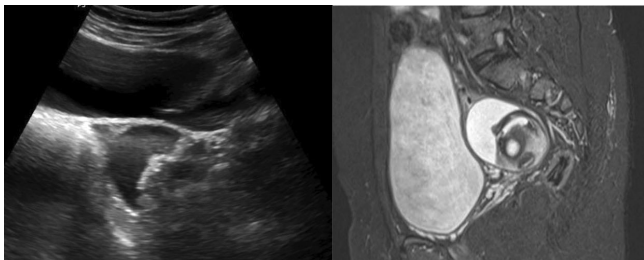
(A): Ultrasound shows a cystic lesion with internal solid component with post acoustic shadowing suggesting possibility of a dermoid cyst. Figure 4(B): FLAIR MRI revealed fat, fluid and solid foci within the lesion and confirmed the diagnosis.
